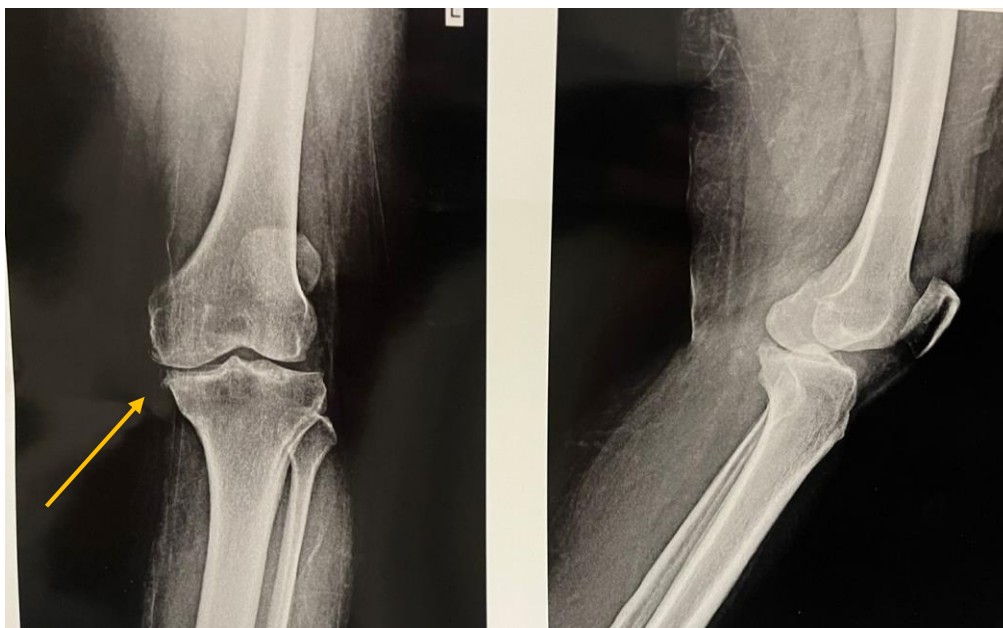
X-ray (A-P and Lateral view) revealed osteoarthritis of knee with minimal joint space narrowing, positive osteophyte formation representing the grade 2 of knee OA according to Kellgren- Lawrence scale.
